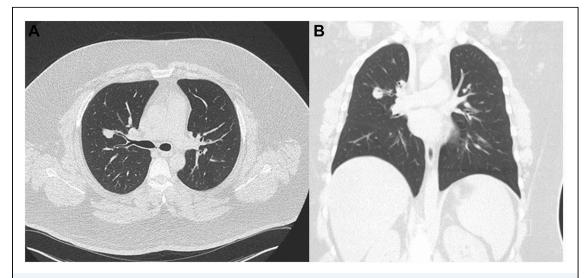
(A) Axial and (B) coronal images on computed tomography of the chest.
